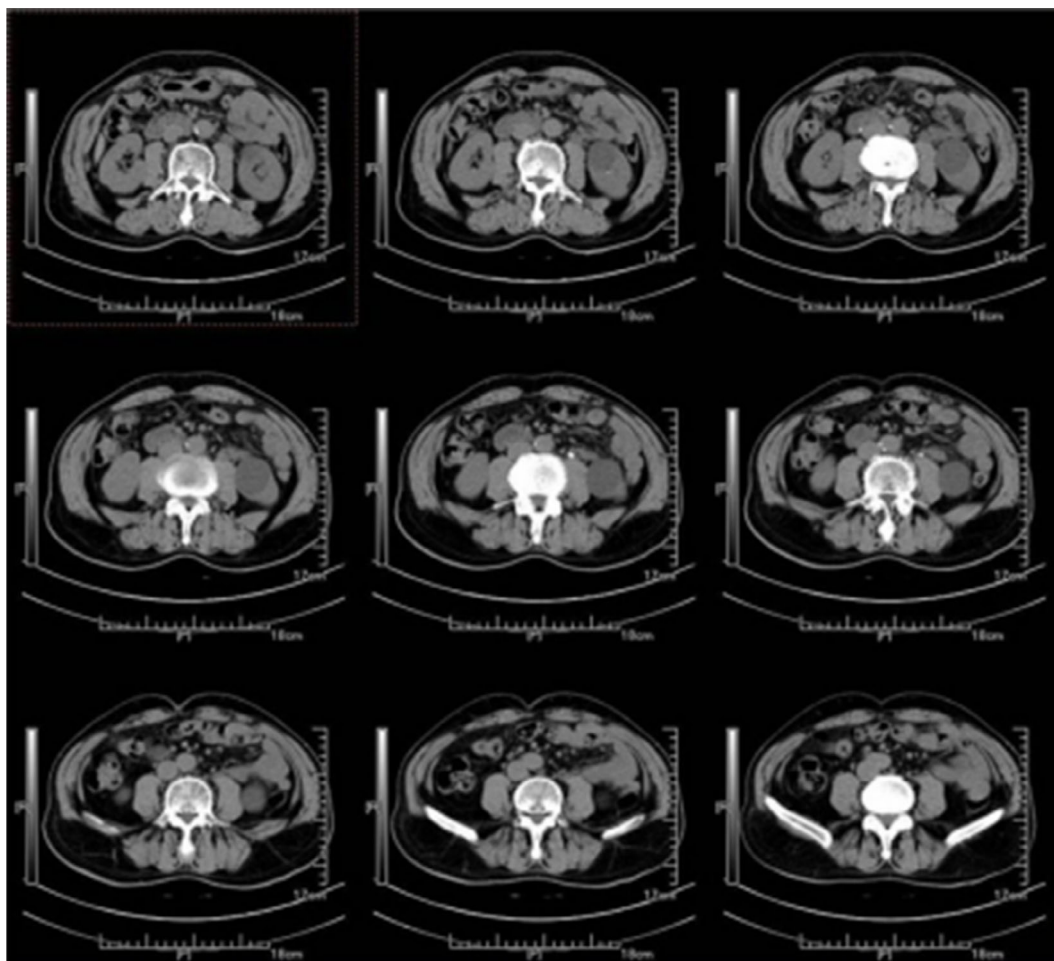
On March 15, CT urography identified a calculus in the right lower ureter and right kidney
